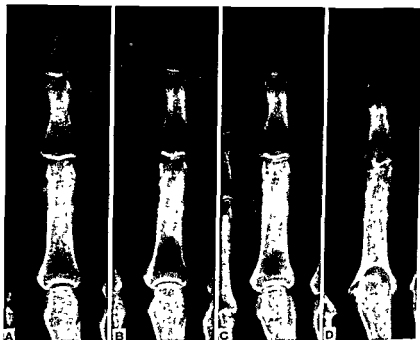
Case V. Serial roentgenograms of the right index finger showing progressive
